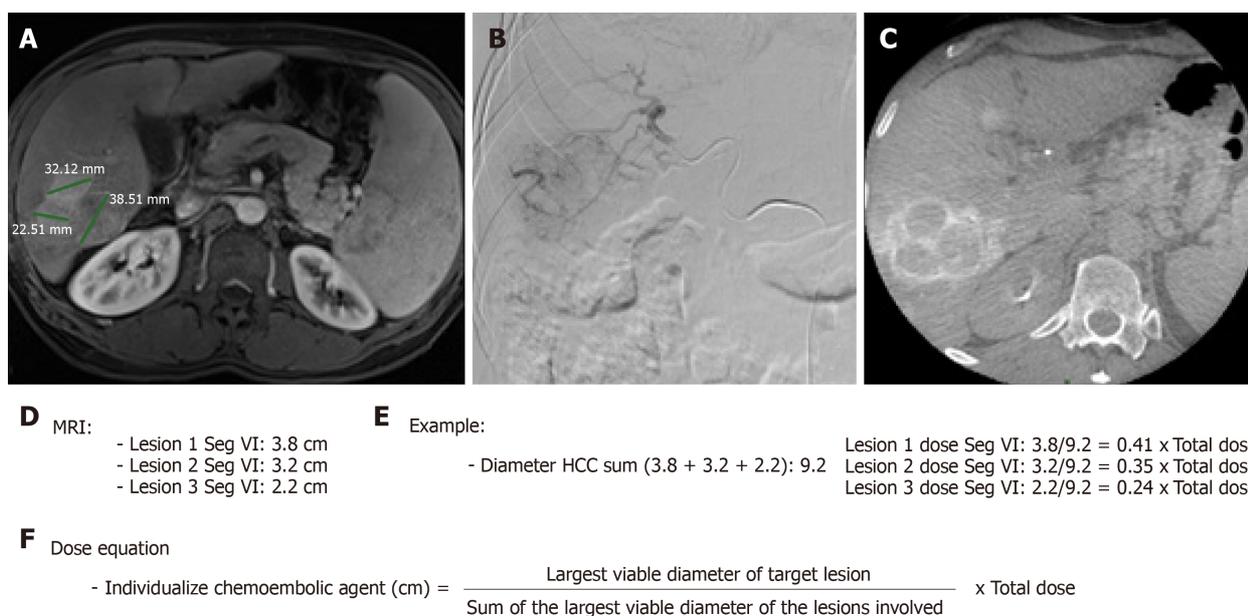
Calculation method for individualization of the dose of the chemoembolic agent received by treated hepatocellular carcinoma in situations of impossibility of the superselective catheterism. A: Magnetic resonance imaging pre-chemoembolization abdomen - post-contrast T1 weighted phase - showing three confluent hypervascular lesions; B: Selective hepatic arteriography in segment VI of the right hepatic artery showing hypervascular lesions characteristic of hepatocellular carcinoma; C: Intraoperative cone beam tomography with selective arterial contrast in segment VI - venous phase - showing three confluent lesions with contrast medium lavage; D: Diameter of hepatocellular carcinomas located in segment VI to be treated; E: Exemplification of the calculation of dose individualization of the chemoembolic agent administered; F: Equation of individualized chemoembolic dose. MRI: Magnetic resonance imaging.
